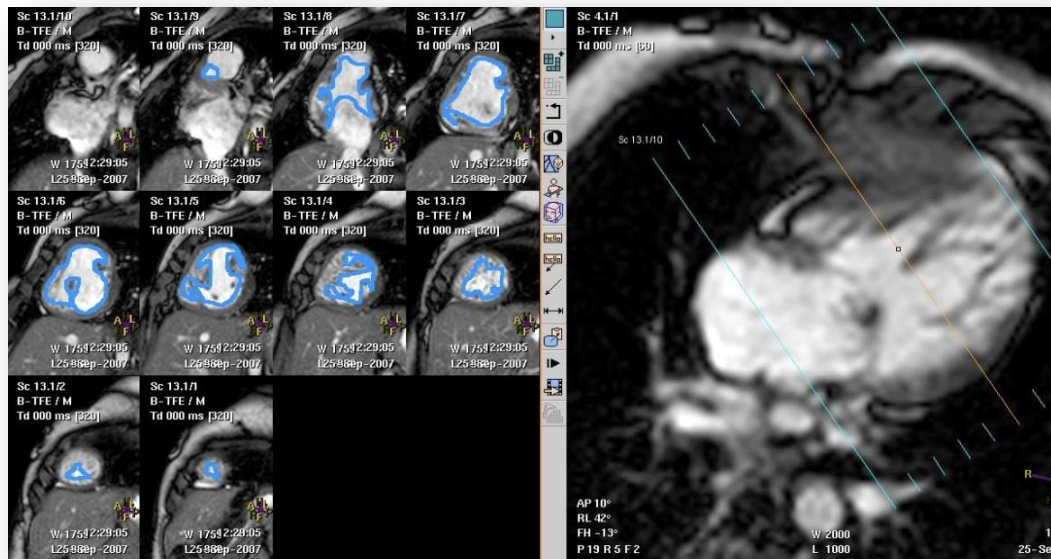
Measurement of EF by MRI from a stack of contiguous slices aligned in the short-axis plane of the tricuspid valve.
